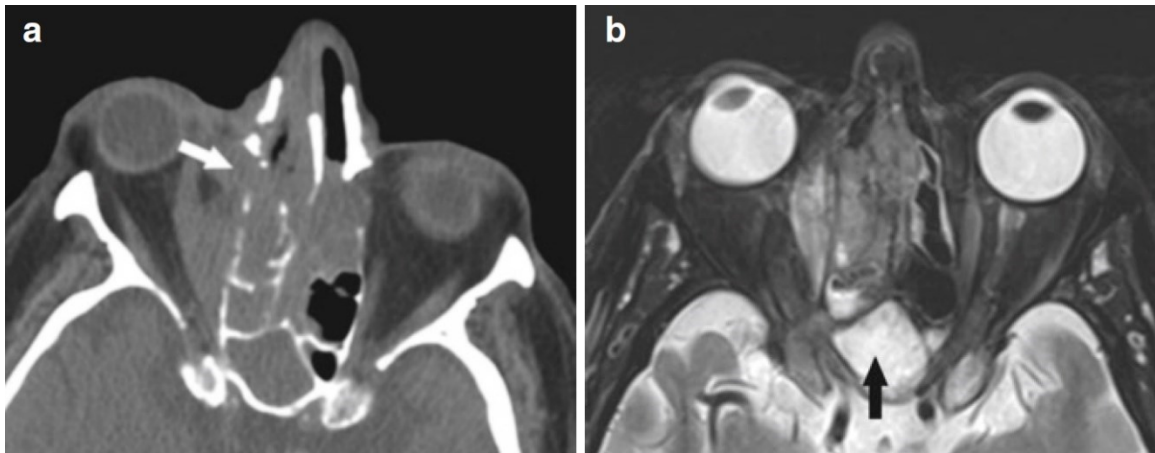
Comparison of sinus CT and sinus MRI. (a) Axial CT images showing a polypoid soft tissue mass centered in the right sinonasal cavity, crossing midline to the left, with extrasinus extension into the right orbit and destructive non-expansile bony changes (*arrow*). This is concerning for an aggressive process (malignancy or aggressive infection in the appropriate clinical scenario). MRI should be obtained. (b) Axial T2w MR images showing an infiltrative mass centered in the right ethmoid air cells, extending into the right orbit, relatively T2 hypointense compared to the benign post-obstructive sinonasal secretions in the sphenoid sinus (*black arrow*). Flanagan CE, Baugnon KL, DelGaudio JM. Radiographic Diagnosis of Chronic Rhinosinusitis. In: Batra PS, Han JK, eds. Practical Medical and Surgical Management of Chronic Rhinosinusitis. Cham: Springer International Publishing 2015:43-72.
